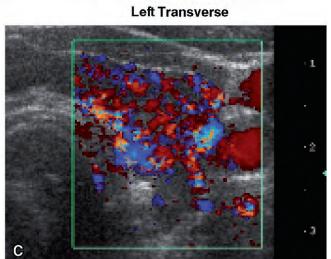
Ultrasound of thyroiditis in both lobes. A, Both lobes. B, Color Doppler, right lobe transverse. C, Color Doppler, left lobe transverse.
